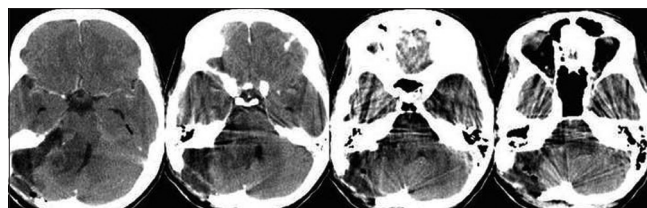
Postoperative computed tomography scan (radical removal of the tumor)
